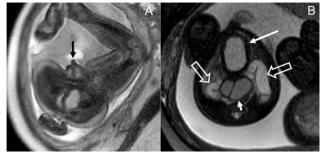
Axial Single Shot Fast Spin Echo (A) and axial Steady State Free Precession (B) MR images of a 32 weeks 6 days fetus showing enlarged clitoris (black arrow in A), enlarged bladder with thickened wall (long white arrow in B), duplicated vagina (short white arrow in B), and bilateral hydroureter (open white arrows in B).
